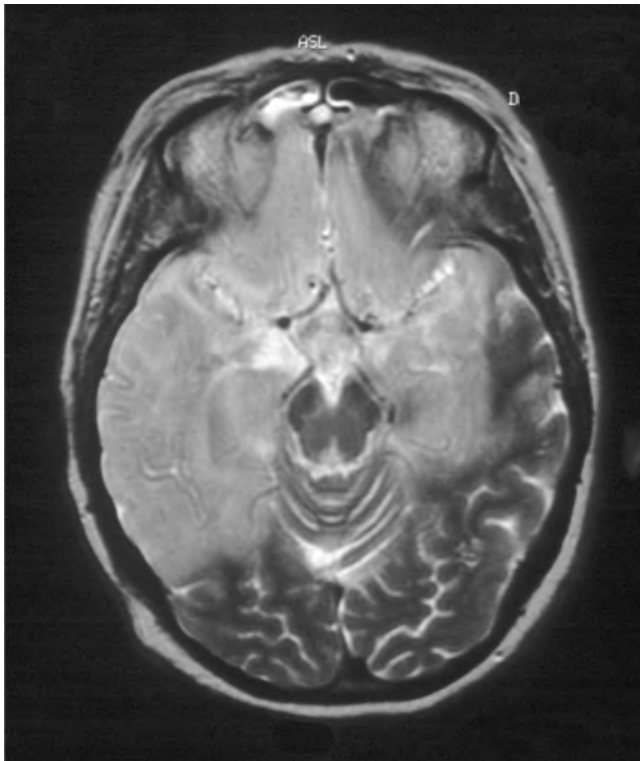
Extensive confluent demyelination in acute disseminated encephalomyelitis (MRI T2W axial).
